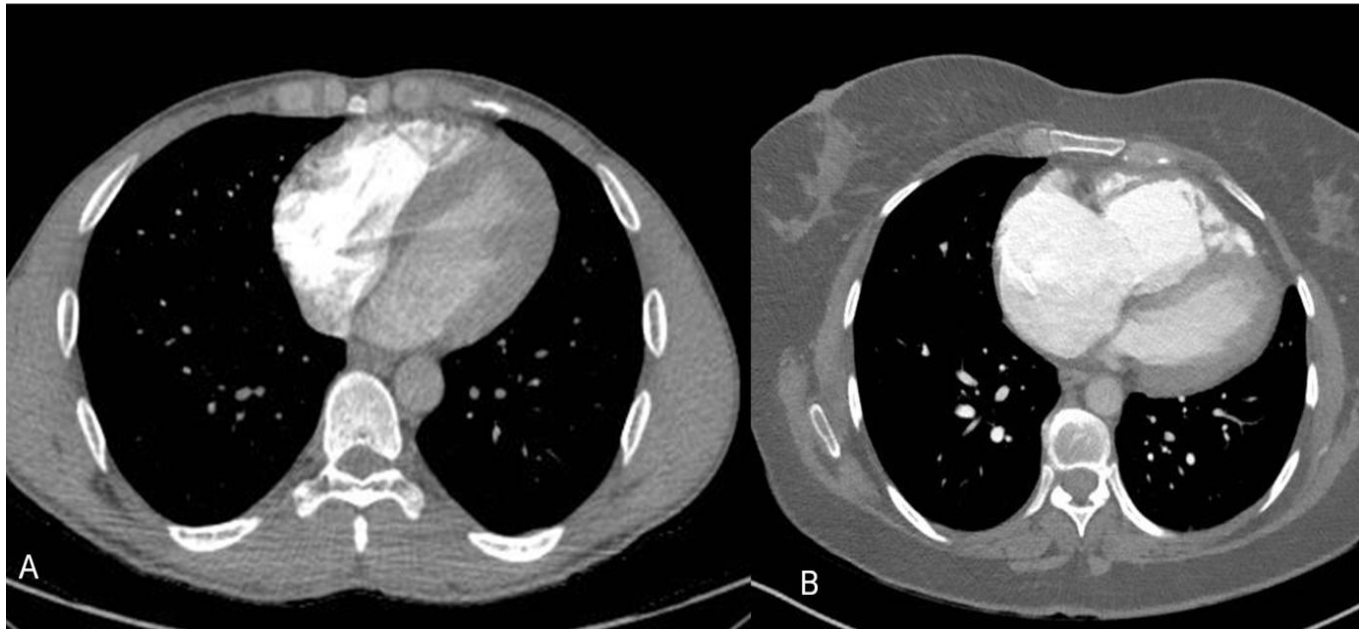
Axial CT images show 'normal' interventricular septum (A) and 'deviated' interventricular septum with convexity towards the left ventricle (B)
